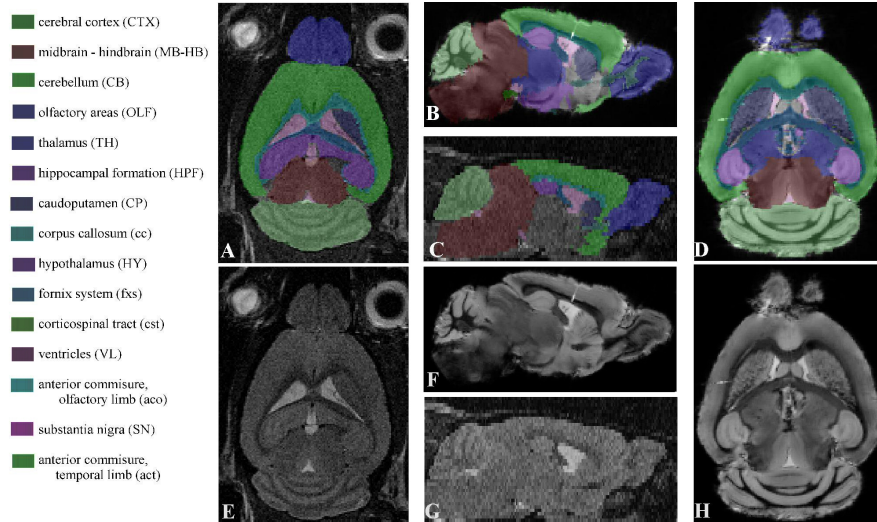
The MRI atlas used for *in vivo*(E,G) and *ex vivo*(F,H) MR images with their manual segmentations (A,B,C, and D) and corresponding names and abbreviations. For a better understanding, the abbreviations for the brain structures are in upper case where the abbreviations for brain tracts are in lower case.
